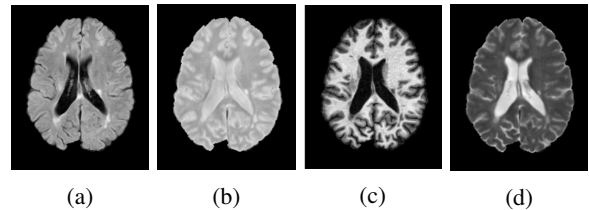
Examples of axial brain MRI images in different modality of acquisition showing MS lesions: FLAIR (a), PD-w (b), T1-w (c) and T2-w (d).
